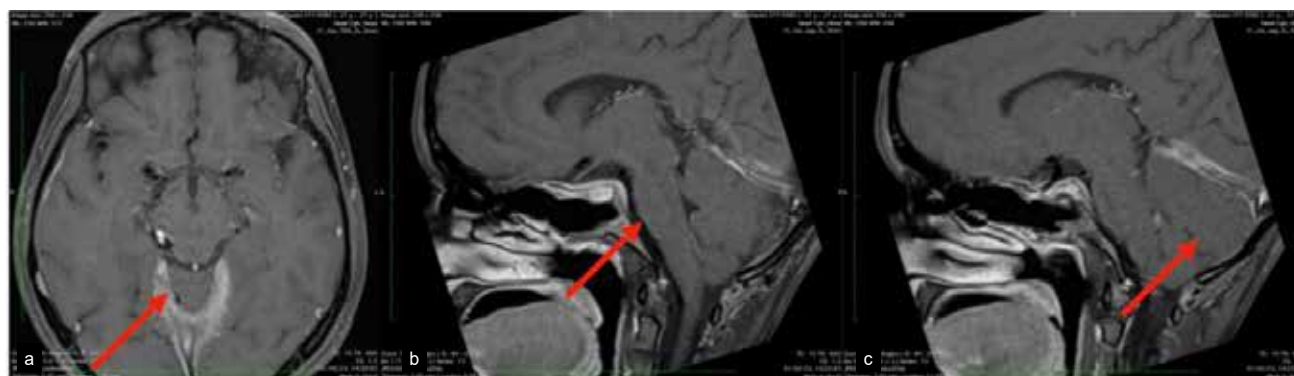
MRI contrast axial-engorged dural venous sinus (a); MRI sagittal contrast flattening of pons (b); and MRI sagittal contrast herniation of cerebellar tonsils (c).
